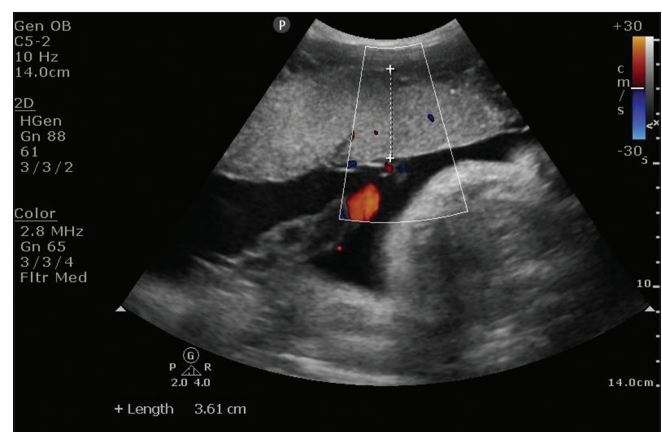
Displays the ultrasonographic measurements for placental thickness at the position of cord insertion
